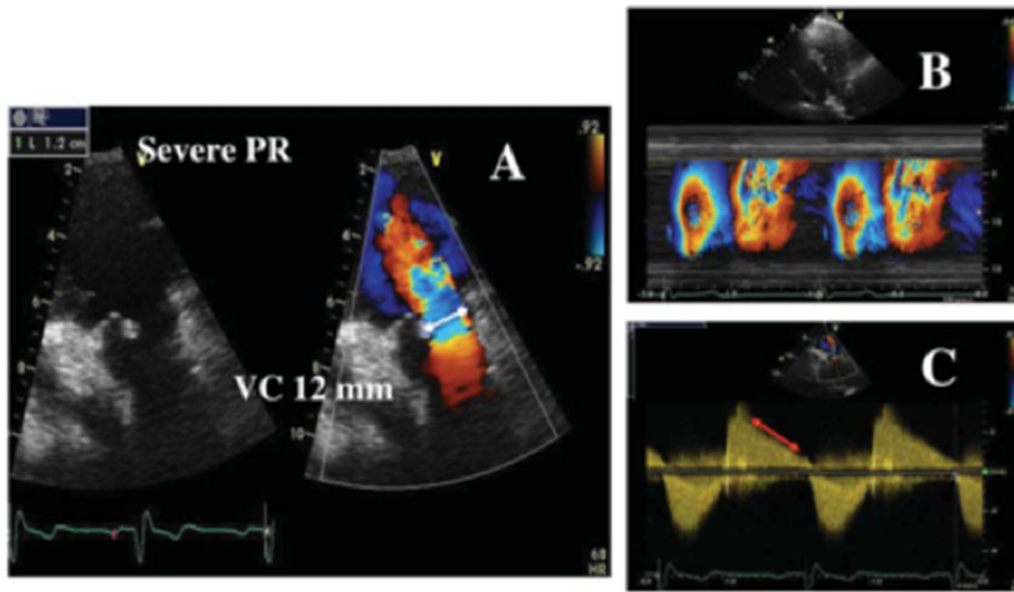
Example of a patient with a severe PR. (A) Left, complete lack of valve coaptation and right, measurement of the vena contracta width (VC); (B) colour-coded M-mode depicting the time-dependency of flow signal during the heart cycle; and (C) Continuous Doppler recording of PR showing a rapid flow deceleration during the diastole (red arrow) and increased systolic flow velocity (not related to concomitant pulmonary stenosis).
